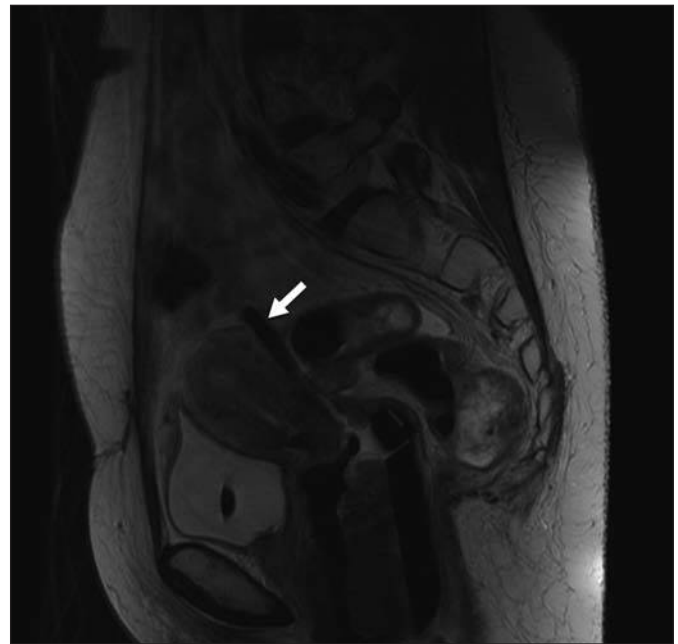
56-year-old woman with cervical cancer imaged after insertion of intracavitary brachytherapy probe. Sagittal T2-weighted MR image reveals that intracavitary brachytherapy probe (*arrow*) has perforated posterior vaginal vault and applicator tip lies in pouch of Douglas.
